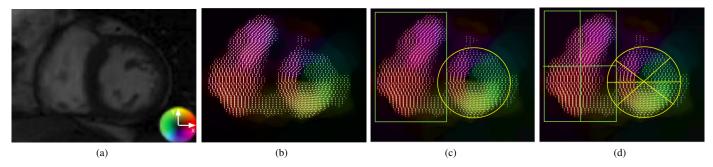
Motion Magnitudes of the Heart. A) Image of interest (MRI). B)First Scale Window. C)Second Scale Window. D) Third Scale Window
